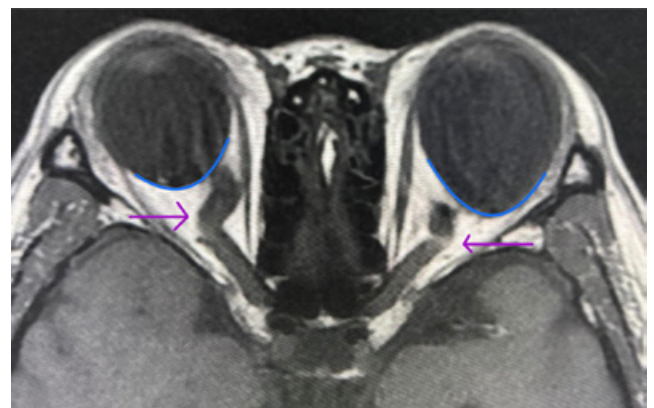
weighted magnetic resonance imaging of the brain and orbit showing bilateral optic nerve tortuosity (arrows) and bilateral posterior staphyloma (curves), more prominent in the left eye.
